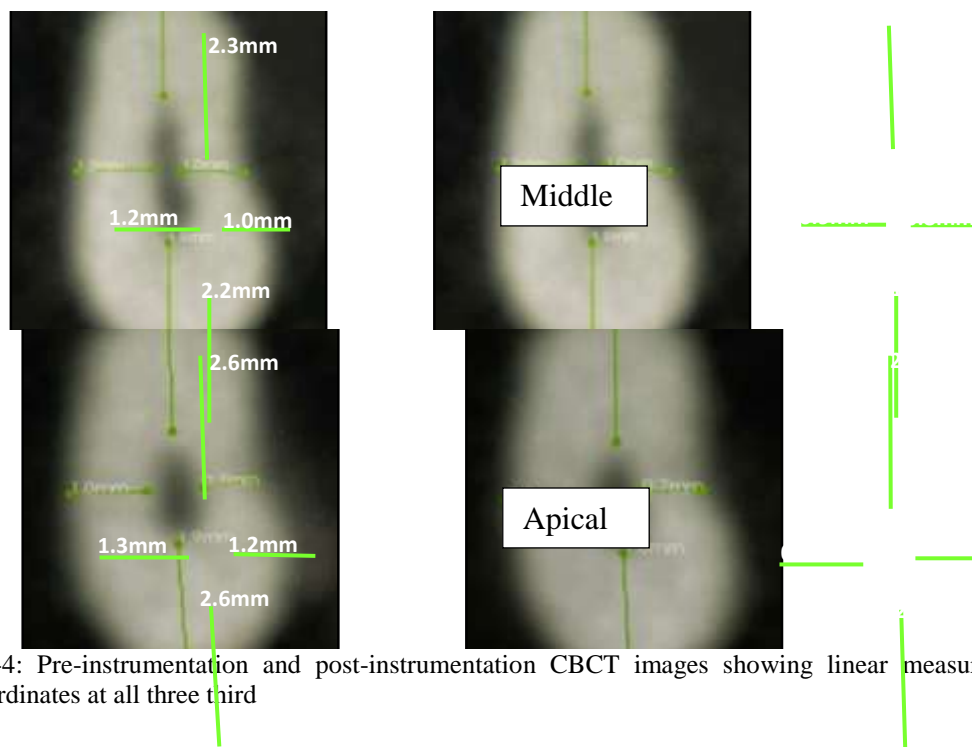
Pre-instrumentation and post-instrumentation CBCT images showing linear measurements for four coordinates at all three third
